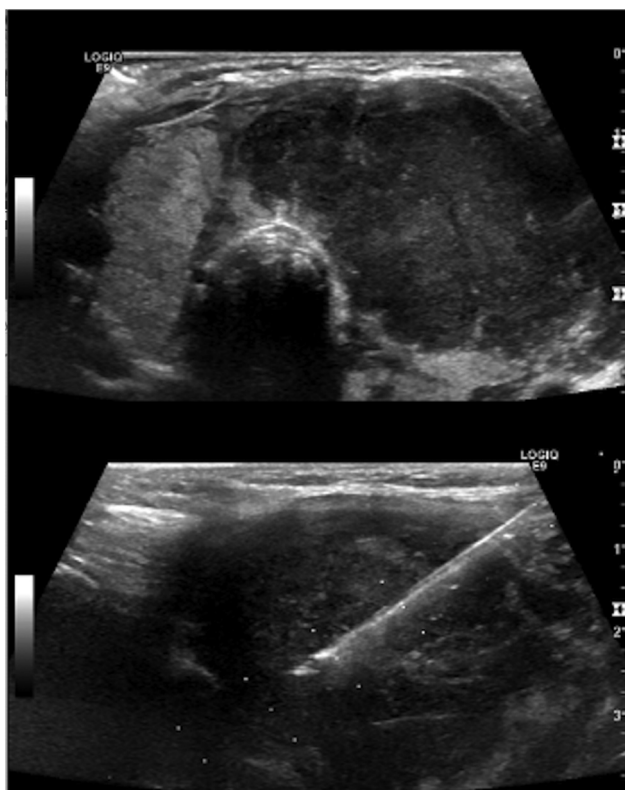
Ultrasound-guided core needle biopsy of a thyroid lymphoma using a 20-gauge needle (top). Left thyroid gland lobe at isthmus level showing the echogenic core needle tip within a hypoechoic solid mass (courtesy Dr. Scott Beasley).
